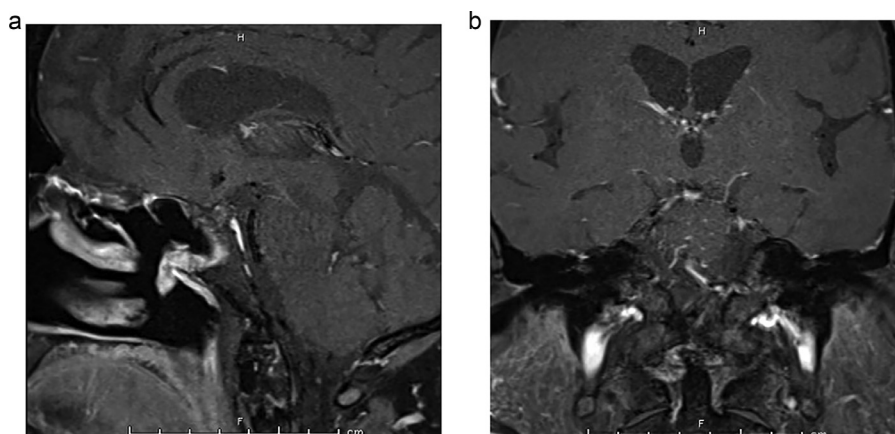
MR imaging of the brain with intravenous contrast in the sagittal (A) coronal and (B) planes on T1 weighted images demonstrated interval resection of the mass with prominent curvilinear enhancement at the posterior aspect of the clivus, in the bilateral parasellar area, and at the planum sphenoid consistent with a small amount of residual mass.
